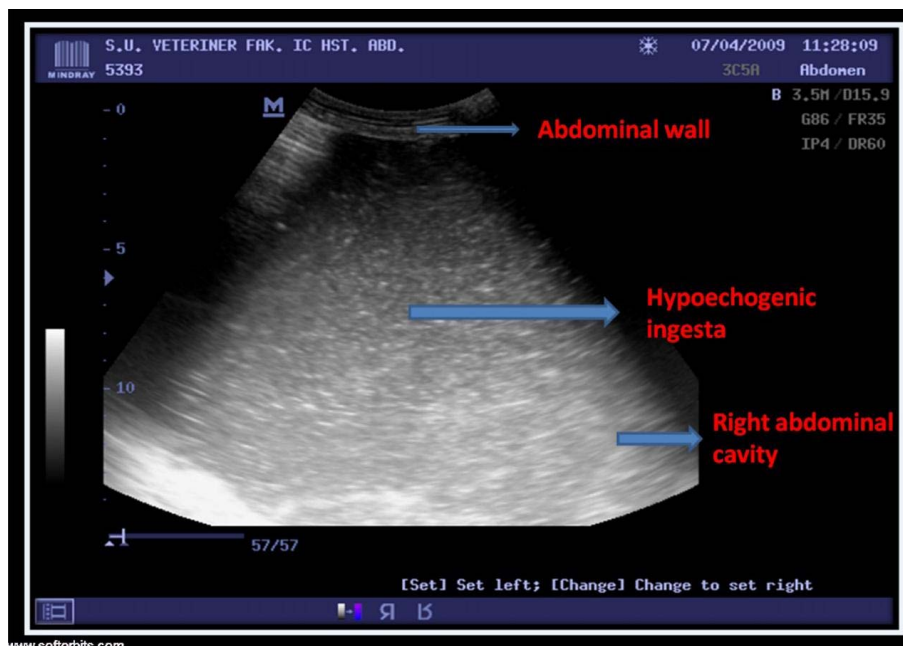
The abomasum and its hypoechoic ingesta by ultrasound examination
